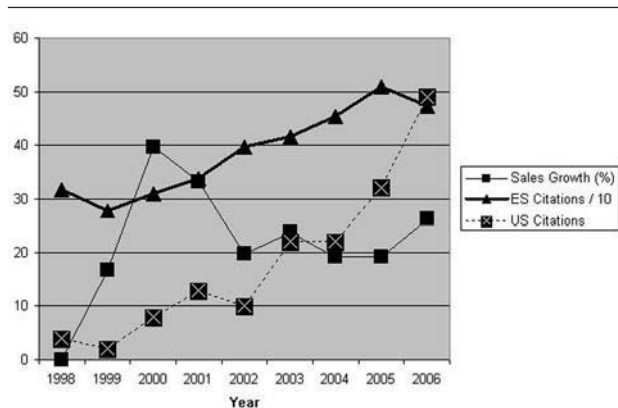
FIGURE Annual sales growth (%) increases when compared with the prior year (with 1998 as baseline) for one vendor's nerve stimulation-related products and supplies are tracked over time. Also tracked are the number (n) of indexed citations of nerve block-related manuscripts describing electrical stimulation (ES) and ultrasound (US). Note that the graphic for ES citations is an order of magnitude greater than for US citations.
